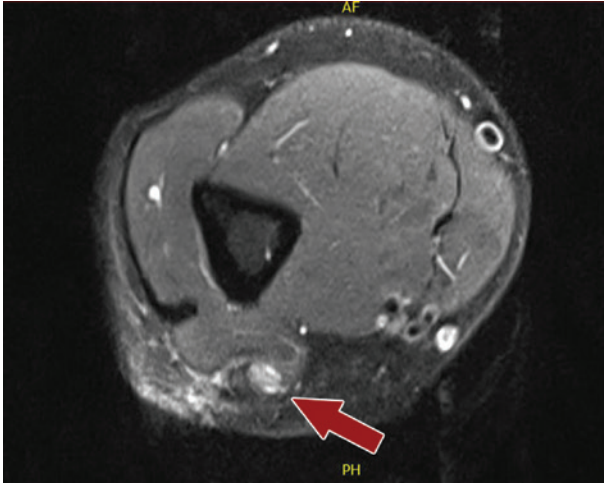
MRI of the right upper arm, axial section, TSE sequence. Red arrow points to the distended right ulnar nerve, which shows significant signal enhancement.
